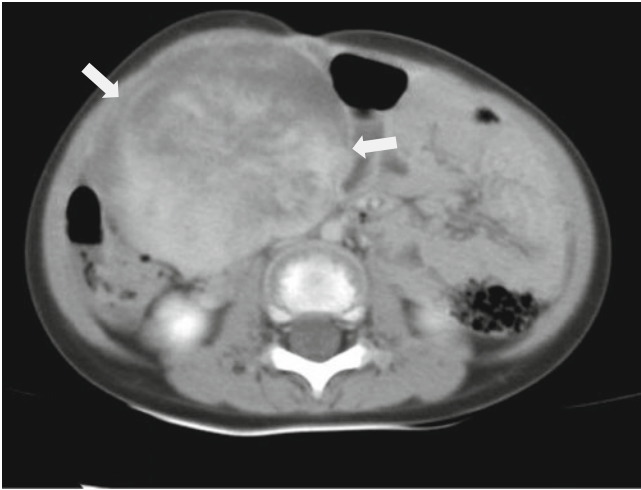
Inflammatory myofibroblastic tumor Axial contrast-enhanced CT shows heterogeneously enhancing solid mass in the RUQ (*arrows*). Excisional biopsy reveals inflammatory myofibroblastic tumor arising from the mesentery
